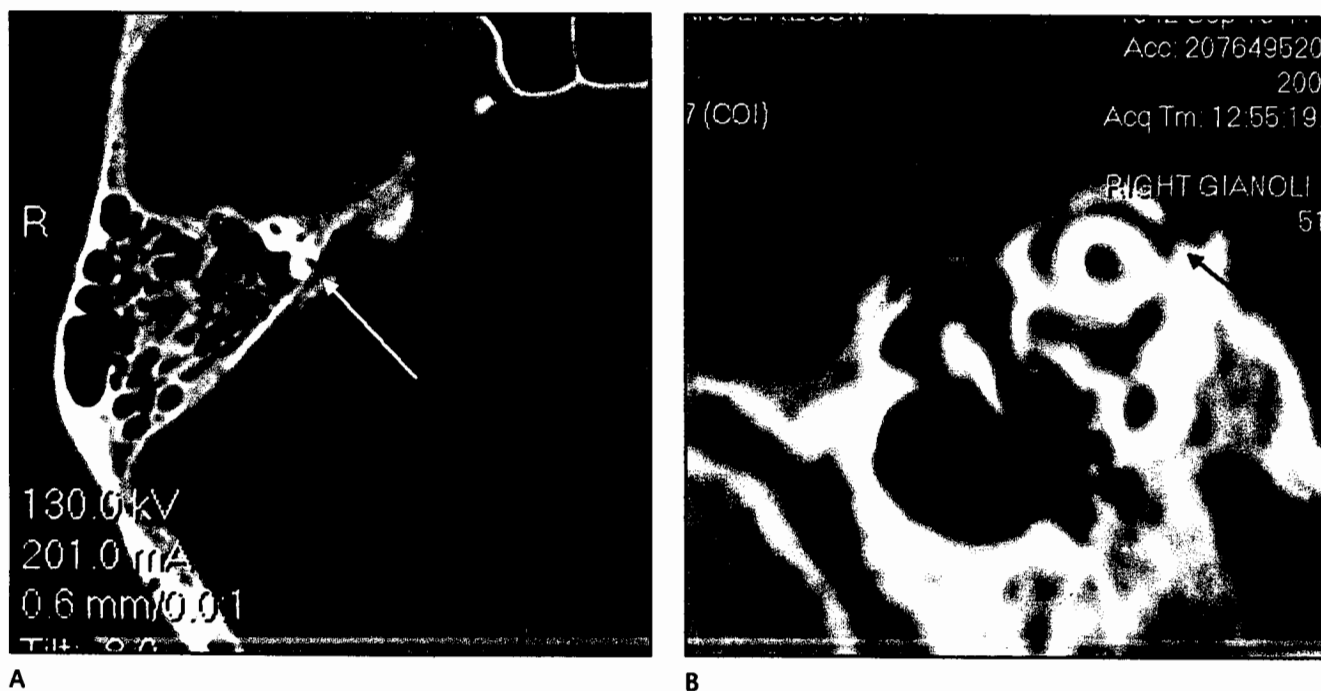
A. Axial CT demonstrating SSCD at the site of the superior petrosal sinus. B. CT reconstruction in the plane of the superior canal demonstrating the corresponding dehiscence at the superior petrosal sinus.
